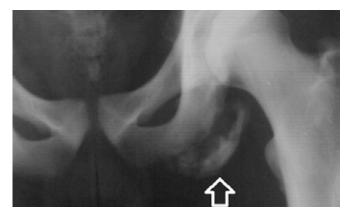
Bony avulsion (arrow) of the hamstring insertion seen on X-ray.
